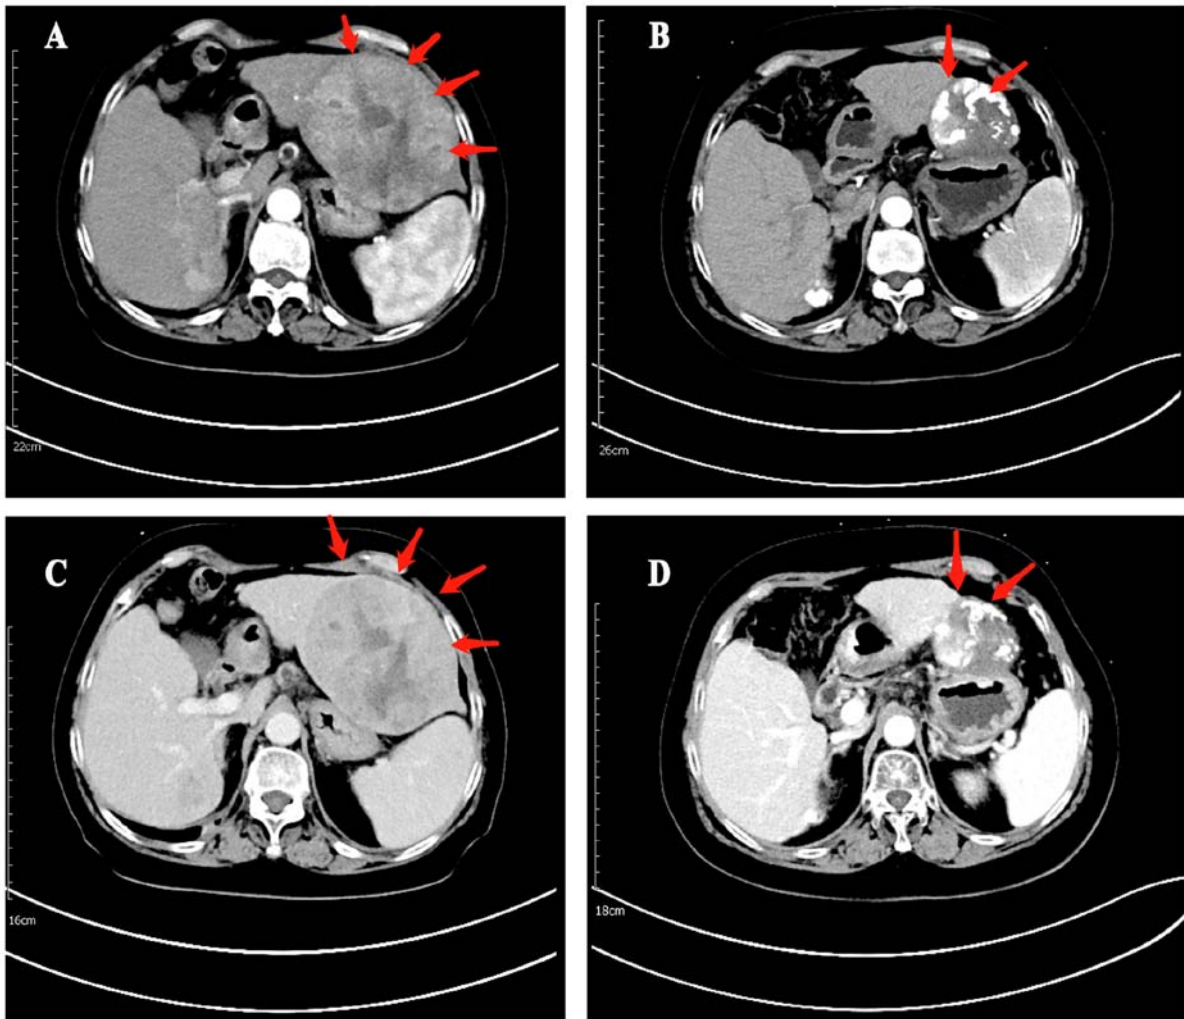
Enhanced CT images in arterial phase of tumor lesions (A) before Len + TACE combination therapy (B) and necrosis and regression of the tumor lesions after Len + TACE combination therapy. Enhanced CT images in portal venous phase of tumor lesions (C) before Len + TACE combination therapy (D) and necrosis and regression of the tumor lesions after Len + TACE combination therapy. Len, lenvatinib; TACE, transarterial chemoembolization; CT, computer tomography.
